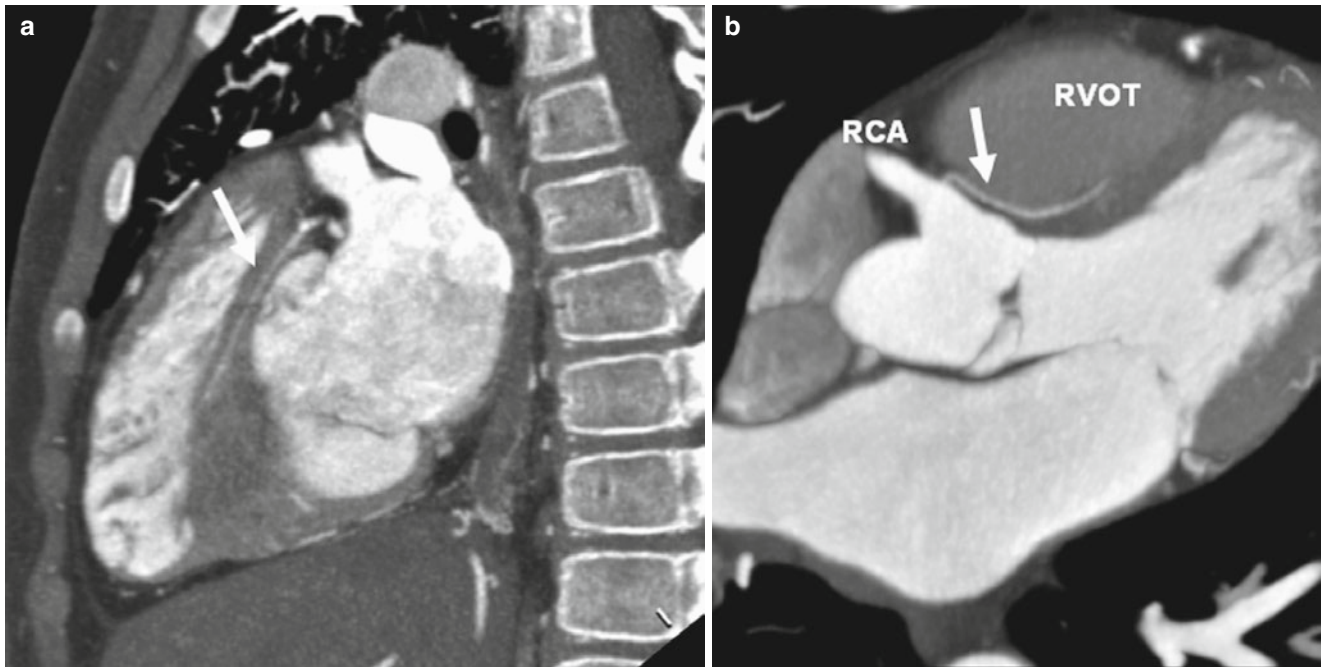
S-shaped sinoatrial node artery (SAAna) (*arrow*) is an anatomic variant of SA node artery originating from the proximal left circumflex (LCx) artery. It can be found in 14% of coronary CT angiographies [7]. The S-shaped SAAna has a predictable proximal
